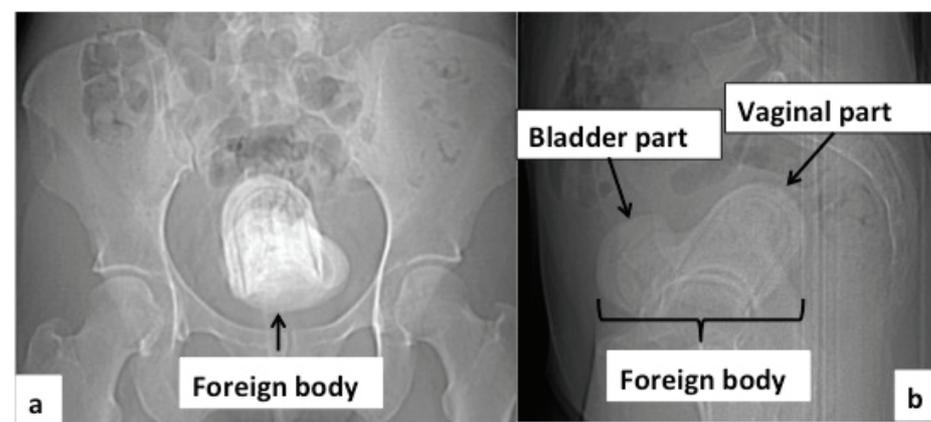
Anteroposterior (a) and lateral (b) pelvic x-ray views demonstrate large calcific shadow in center of pelvis.
